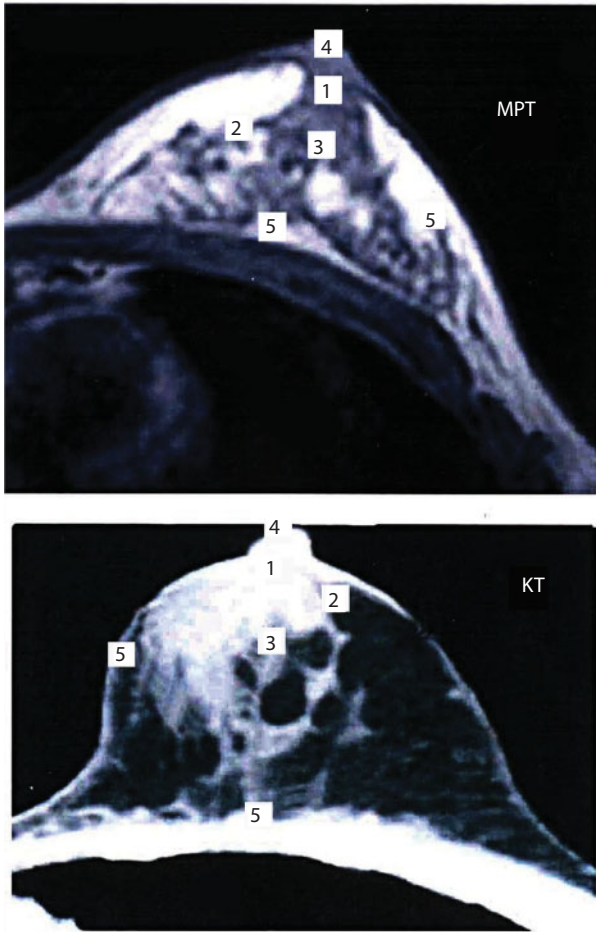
MRI and CT of the breast.
